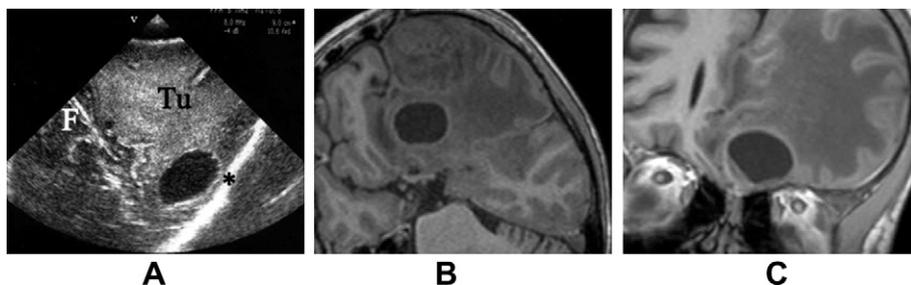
(A) Coronal ultrasound showing clear visualization of the tumor, the falx and the skull base compared to (B) axial and (C) coronal T1-weighted intraoperative MRI. F = falx, Tu = tumour, * = skull base.
